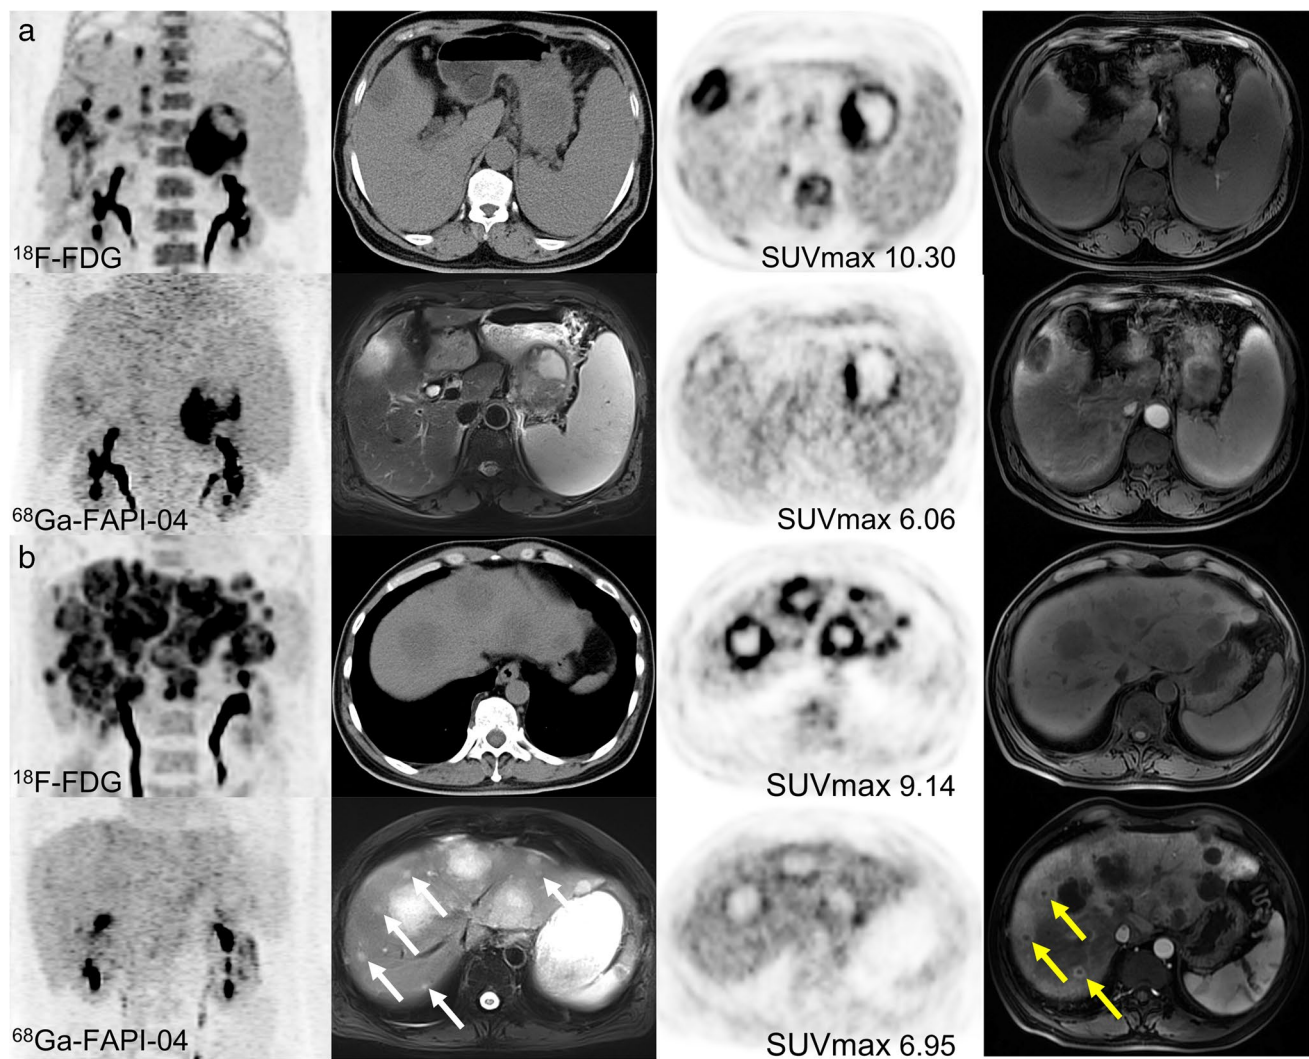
In two liver metastatic patients with pancreatic tumours, ^{68}Ga -FAPI-04 uptake was detected at only the edge of liver metastases, and the ^{18}F -FDG uptake intensity was more obvious. All intrahepatic metastases with increased ^{18}F -FDG metabolism were detected by
